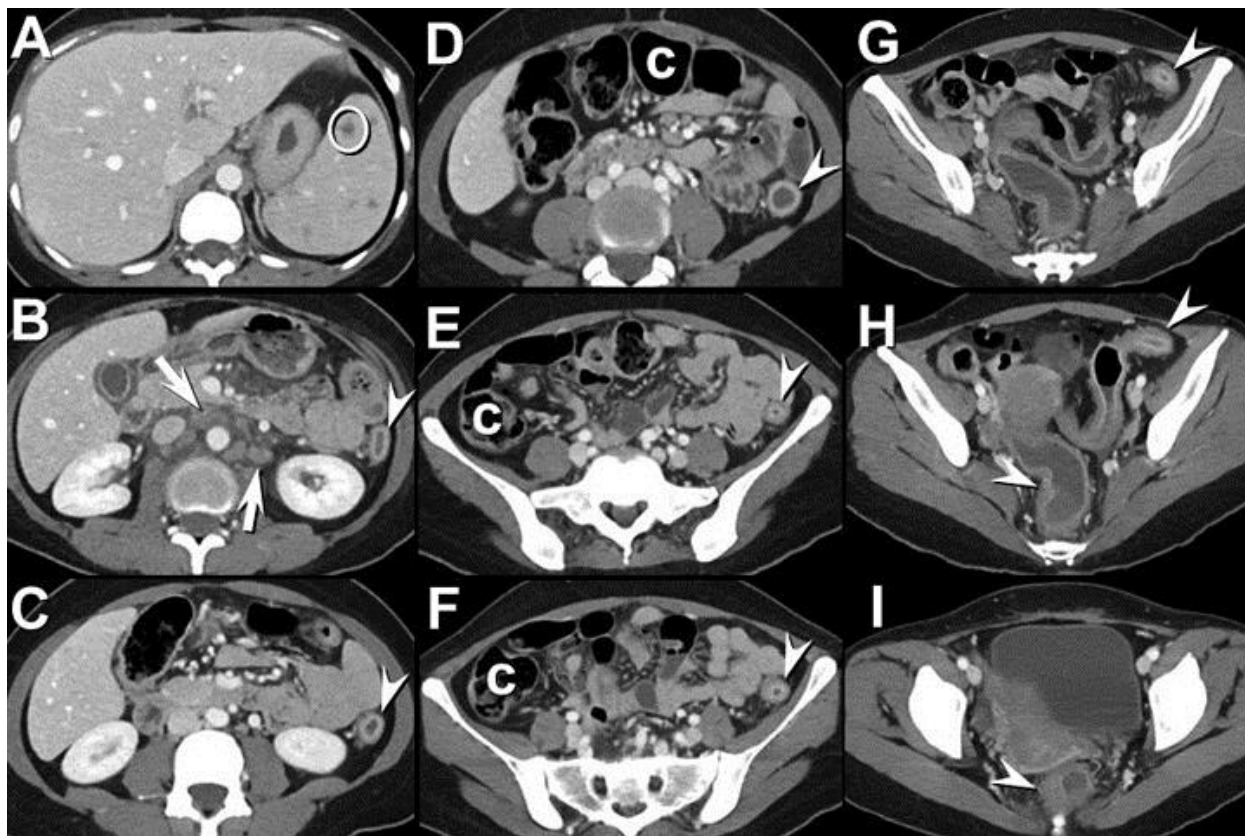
Figure 1A-I: Axial enhanced abdominal CT shows diffuse colonic thickening extending from the distal transverse colon through the rectum (arrowheads) as well as retroperitoneal lymphadenopathy (arrows). Small non-specific hypoattenuating splenic lesions (circle) and nonspecific gallbladder wall thickening are also present. c = normal right and transverse colon; note thin wall.
